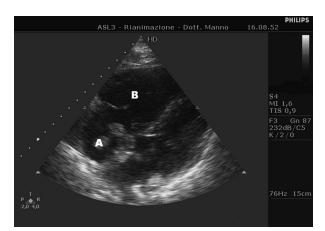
Image of the right atrium clot (A), dilated right ventricle (B), and small-sized left ventricle in apical 4-chamber view.
